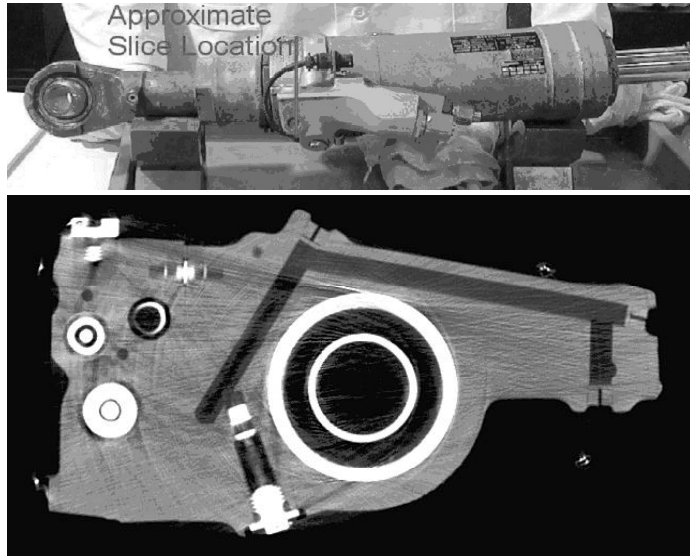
Airbus A300 servoactuator (top), axial slice CT image (bottom).
